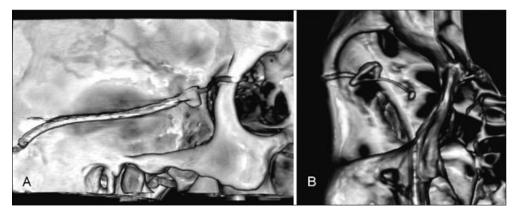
3D reconstruction of computed tomography scans of one patient approximately 2 years after implantation. (A) Side view of the reconstruction which shows the path of the silicone cable from the retro-auricular region through the temporal fossa around the lateral orbital rim. The ticker part in the temporal fossa is the transition from the silicone cable to the polyimide foil. (B) Frontal view showing the polyimide foil within in the orbit, the episcleral part and the subretinal part where the thicker ending of the implant constitutes the microphotodiode array and the direct stimulation electrodes.
